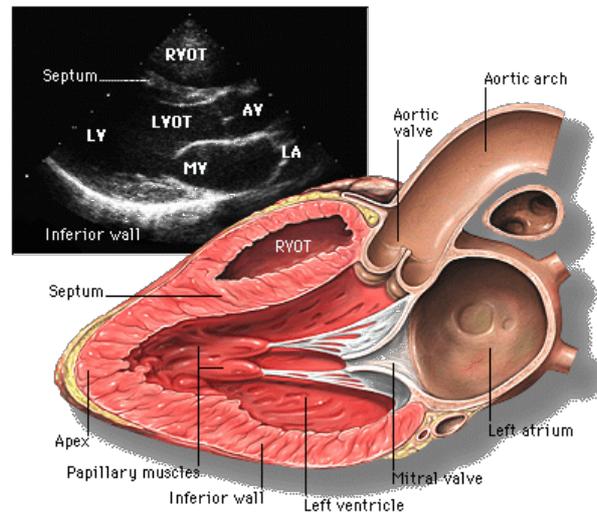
Parasternal long axis view: http://www.med.yale.edu/intmed/cardio/echo_atlas/contents/index.html
